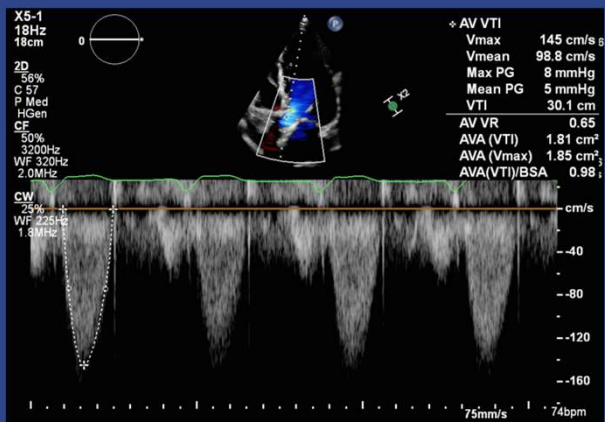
Apical CW Doppler across post-op TAVR at 1 year, from author's clinical collection, di-identified (M.Trump, 2025)
